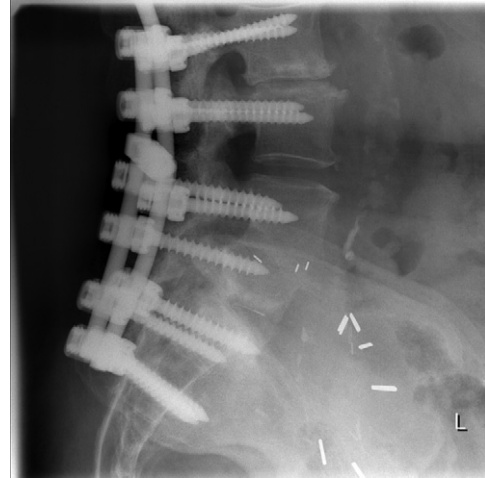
Lateral X-ray showing infected hardware removed, clearance of infection, reinstrumentation, and fusion of spine.
